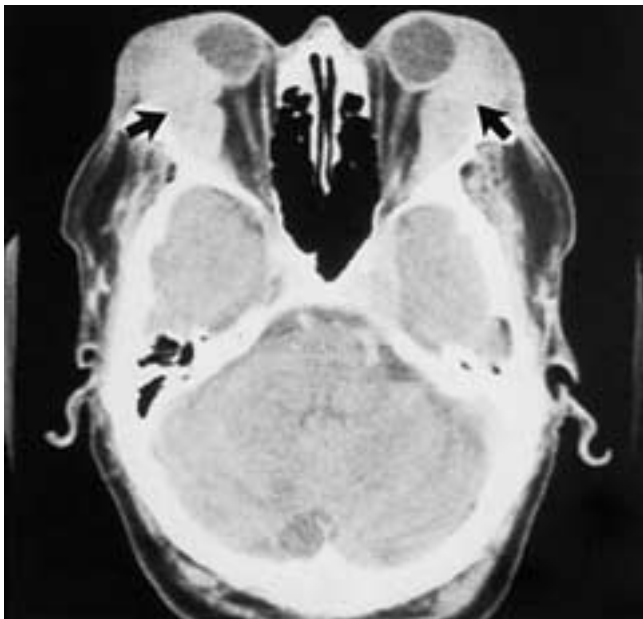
Lacrimal gland pseudotumor. An 80-year-old patient with swelling of both eyes. Axial postcontrast CT scan shows bilateral lobular enlargement of the lacrimal glands (arrows).
